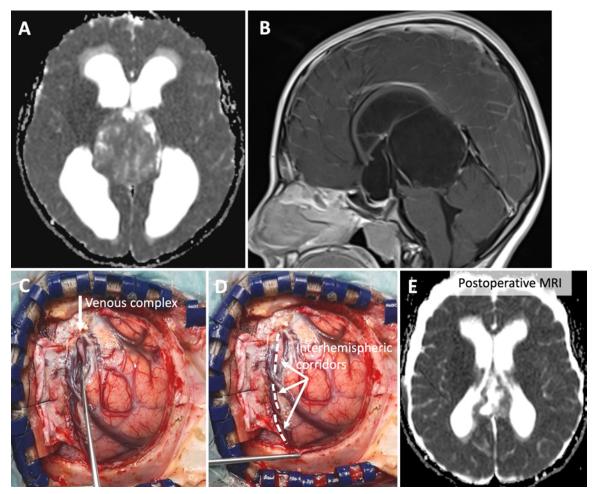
Type 3 case example in a 12-year-old male. Preoperative axial diffusion-weighted image (A) and postcontrast sagittal MR image (B) showing a sizable epidermoid tumor of the quadrigeminal cistern. A right parietal craniotomy crossing the midline SSS with an interhemispheric approach was performed after placement of an external ventricular drain (C). Upon opening the dura, a type 3 venous complex configuration draining into the SSS posterior to the coronal suture was identified. Individual draining veins were skeletonized, and an interhemispheric corridor was developed for microsurgical tumor resection (D and E).
